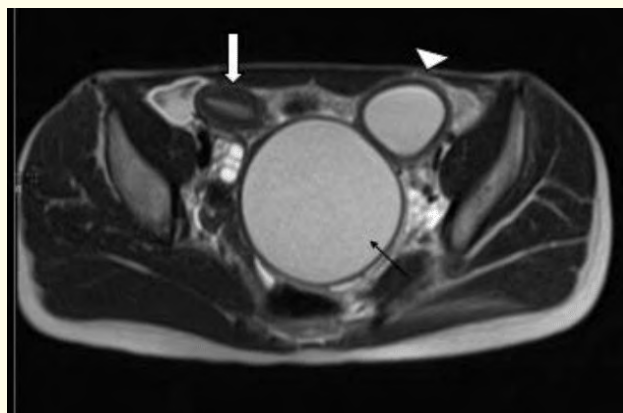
MRI: Axial T2WI shows dilated vagina (thin arrow), left uterine horn (arrowhead) and normal right uterine horn (arrow).
